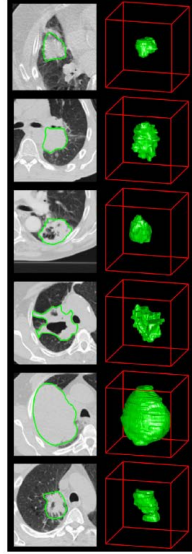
Example computed tomography (CT) images of lung cancer patients. CT images with tumour contours [2].
